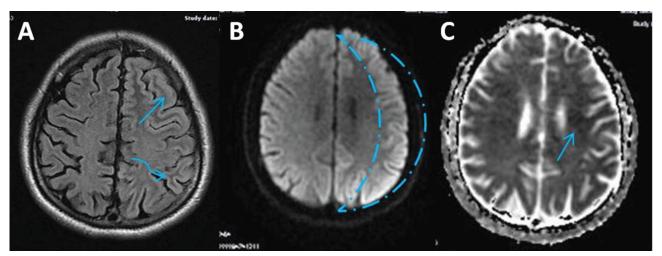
Axial FLAIR (A) and Diffusion-MR image (B,C) of the brain of a 20 year-old MELAS case show global left hemispheric cortical thickening and hyperintensity.
